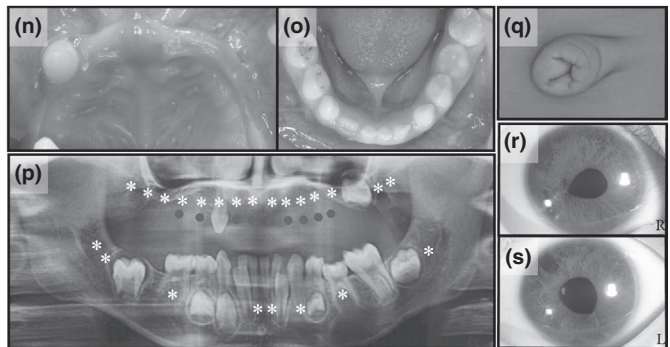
Clinical features of probands. Intra-oral photographs of proband #607 (a and b), #577 (g and h), and #535 (n and o). (c, i, m, and p) Panoramic radiographs of four probands. (d, j, and q) Umbilical photographs of proband #607, #577, and #535. Ocular symptoms of the proband #607 (e and f), #577 (k and l), and #535 (r and s). White asterisks indicate congenitally missing permanent teeth. Red circles indicate congenitally missing primary teeth. R, right side; L, left side [Colour figure can be viewed at wileyonlinelibrary.com]
